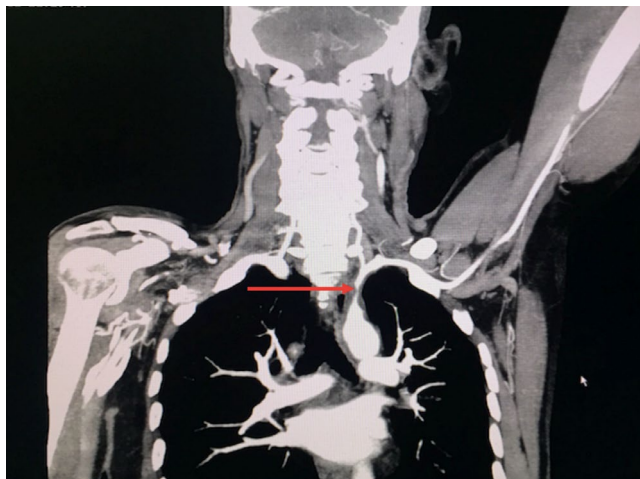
MDCT (Multidetector Computed Tomography) angiography of the neck vessels showing partial obstruction of left subclavian artery (red arrow) proximal to the origin of left vertebral artery
